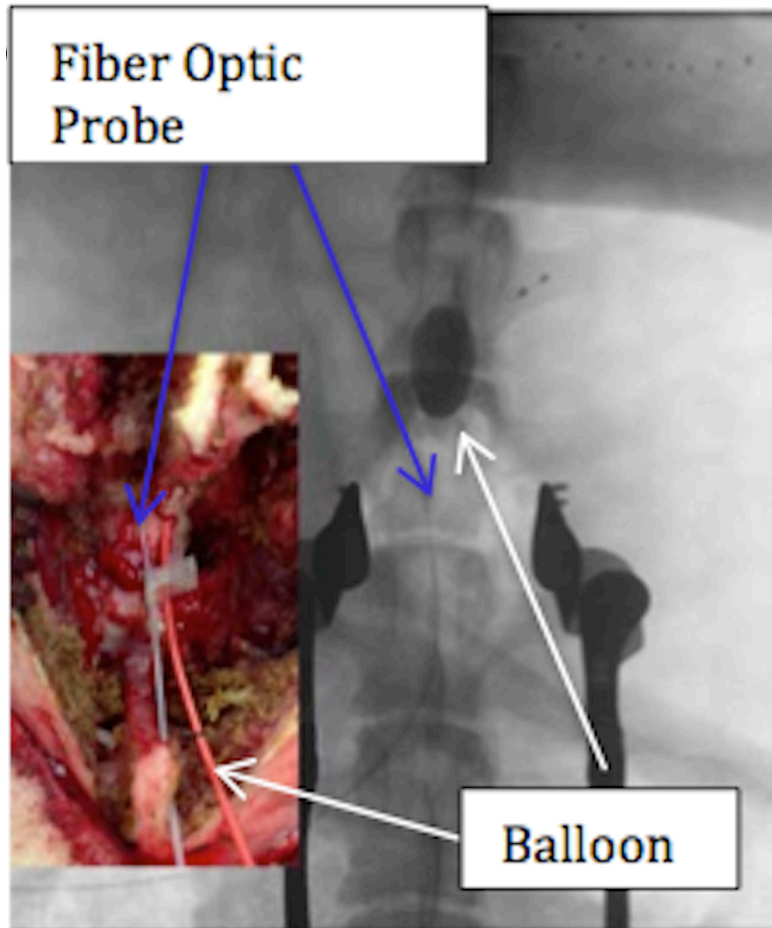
The radiographic image shows the epidural balloon placed directly on top of the spinal cord tissue, and adjacent to the fiber-optic probe. In this case, the balloon has been inflated, thus crushing the spinal cord. The inset image shows a picture taken during the experiment wherein the fiber-optic probe and epidural balloon were placed under direct vision following a laminectomy, to lie adjacent to each other on top of the spinal cord tissue.
